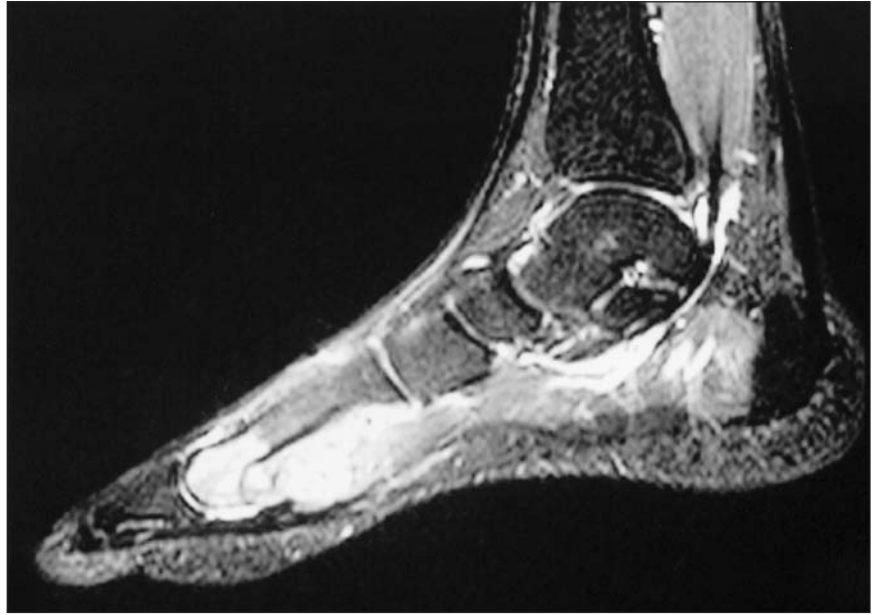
Sagittal STIR weighted magnetic resonance image showing focal bone marrow changes.
